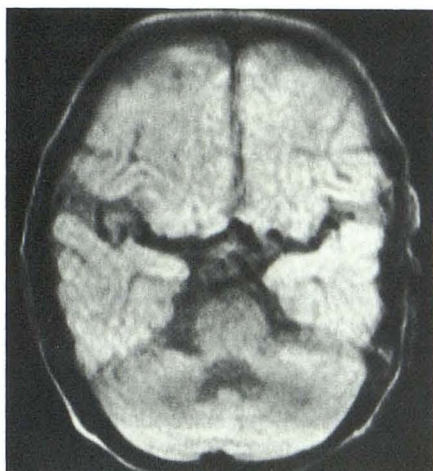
Spin-echo axial MR image (TE = 56/TR = 1999) of 12-year-old boy shows tortuosity of both middle cerebral arteries.
